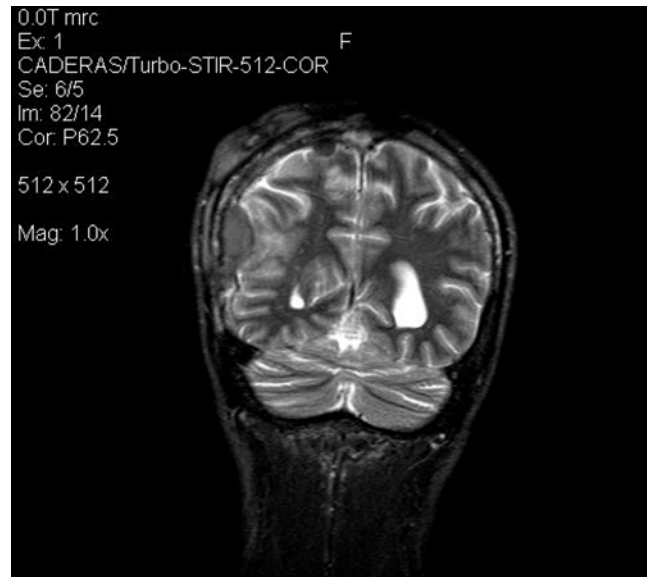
Brain MRI (coronal turbo short tau inversion recovery (STIR) imaging) showing both lesions
